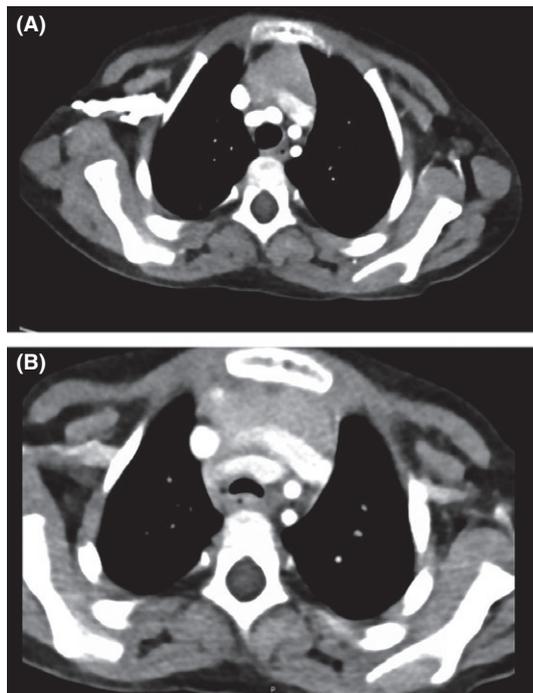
A, CT image at the level of the brachiocephalic artery during inspiration. B, CT image at the level of the brachiocephalic artery at end exhalation demonstrating approximately 53% collapse
